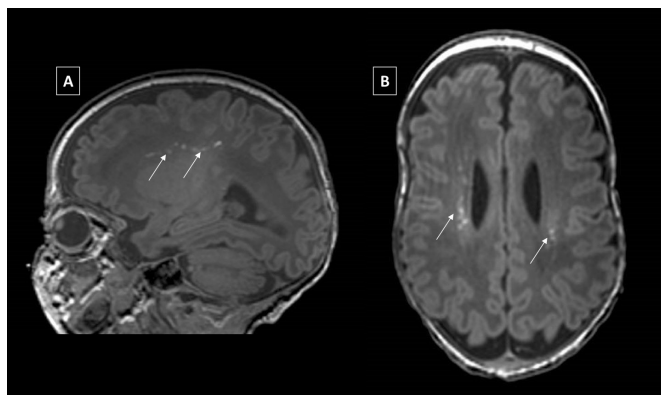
MRI images—preterm infant. Punctate white matter lesions (PWMLs) in a preterm infant born at 32 weeks+3 days and imaged at 40 weeks+5 days in the sagittal (A) and high axial plane (B). PWMLs are small areas of white matter injury and are the most common lesion type seen on MRI in ex-preterm babies imaged at term. PWMLs are typically defined as small foci of high T1 signal in the white matter, less often visualised on T2 sequences. PWMLs detected on a single MRI at term-equivalent age without other focal lesions or injuries in the grey matter have been associated with abnormal neuroanatomical development and adverse motor outcome at 20 months.
